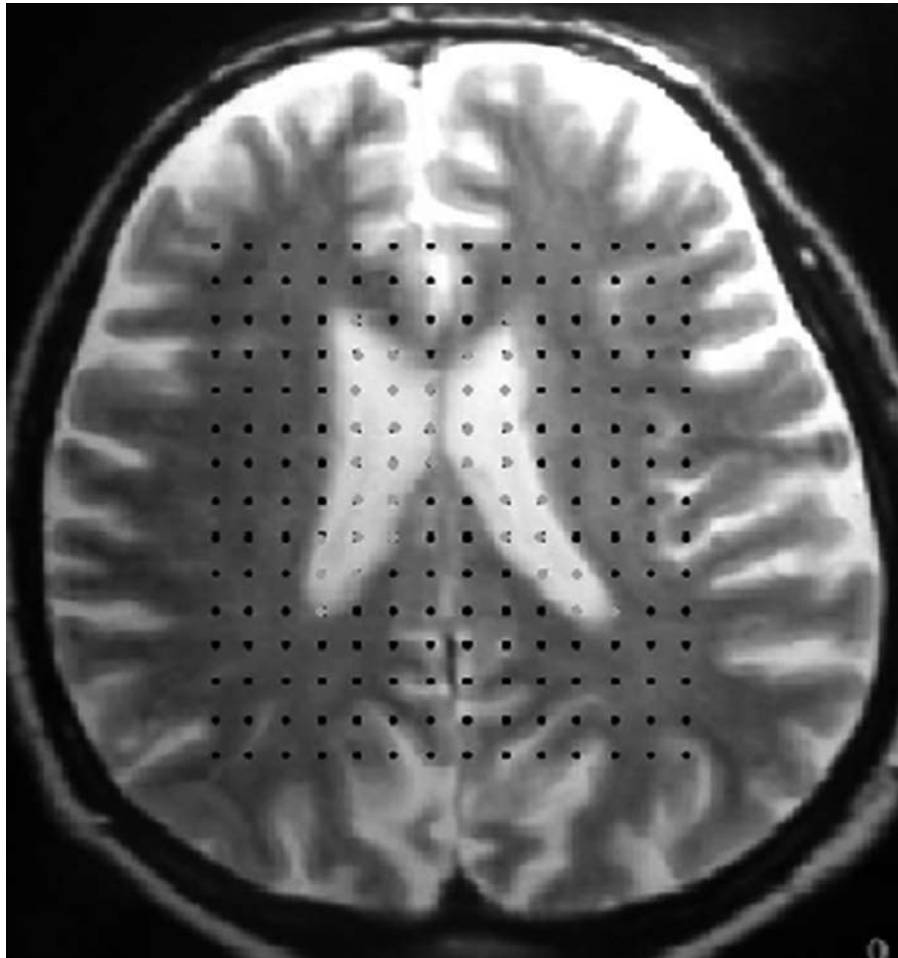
Axial MRI scan of a human brain with a transparent test system superimposed. For the Cavalieri estimate of total ventricular volume every point that hit the ventricle was counted as a P_i . Here, 37 points (grey) hit the ventricle
